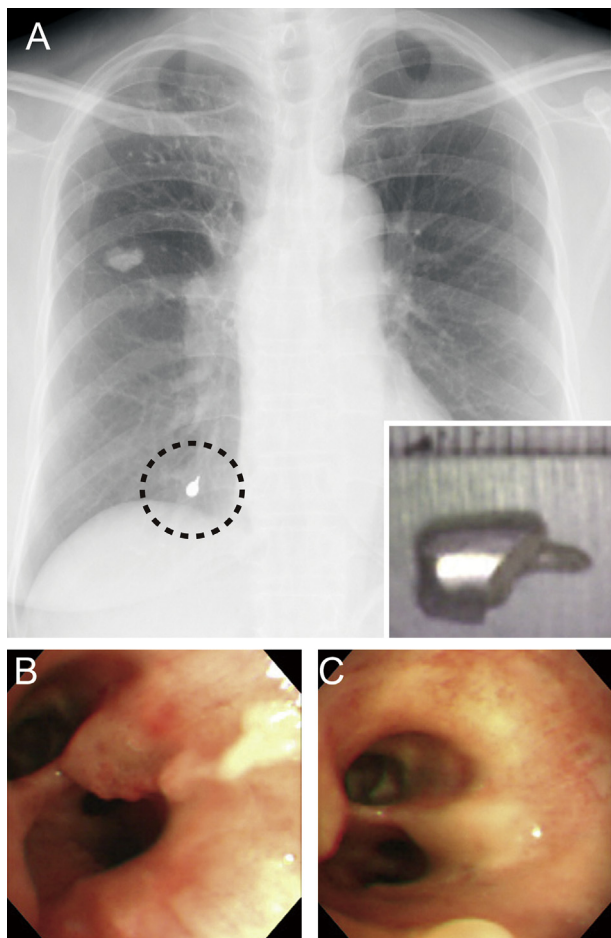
a) Chest radiograph showing a radiopaque object in the right lower lung field (dotted circle). The inset image shows the retrieved dental prosthesis, 10 mm × 5 mm, with a scale bar. b) The bronchoscopic image shows mucosal redness, edema, and granuloma formation in the right basal bronchus. c) A bronchoscopic image taken after 4 days of prednisolone administration shows improvement of the mucosal inflammation.
